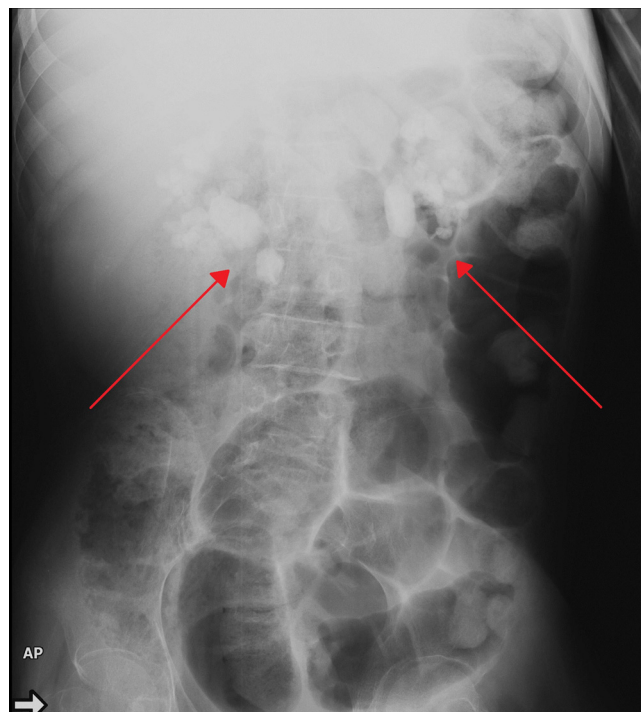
Abdominal X-ray. The presence of staghorn calculi in both kidneys and separated stones localized in the kidney pelvis-ureteral junction (arrows)
